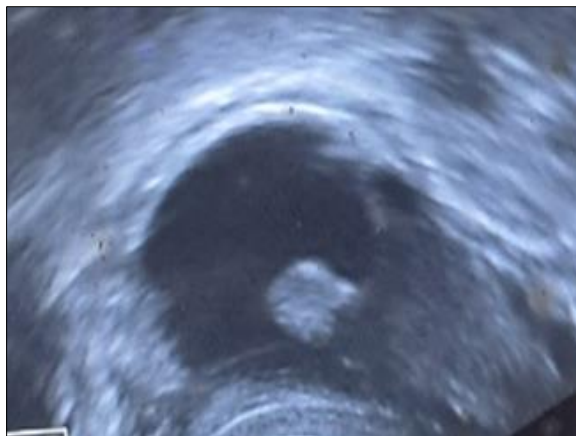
Ultrasonographic image showing blood filled follicle on day 7 post-TVOR
